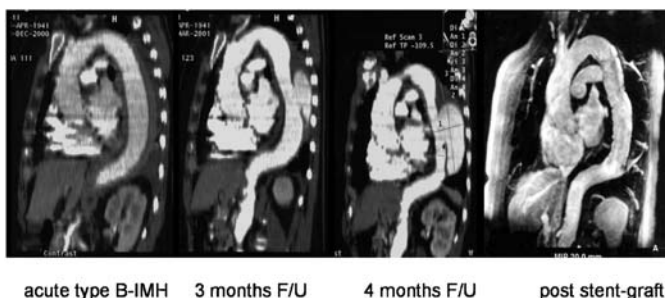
Evolutions of acute IMH of the descending aorta (*left*) to growing local dissection and formation of an aneurysm on spiral contrast-enhanced computed tomography scans within 4 months; reconstruction of the dissected aorta and exclusion of aneurysm after interventional stent-graft placement. *F/U* follow-up
